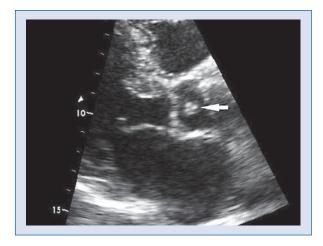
A 63-year-old male with a papillary fibroelastoma arising from the aortic valve presenting with recent fatigue. Echocardiography (long axis view) showed a round, dense, multilobulated, pendulated mass (arrow) attached to the right cusp of the aortic valve.
